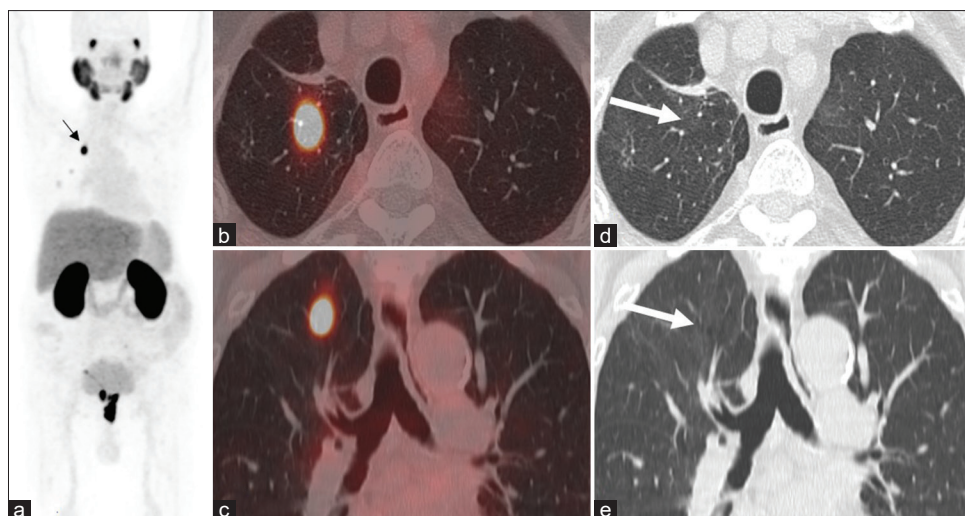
Maximum projection intensity (a) image shows intense focus of uptake in the right lung region, which corresponds to focal prostate-specific membrane antigen uptake on axial and coronal fused positron-emission tomography/computed tomography images (b and c); however, no morphological lesion is seen on axial and coronal computed tomography images (d and e) in lung window
